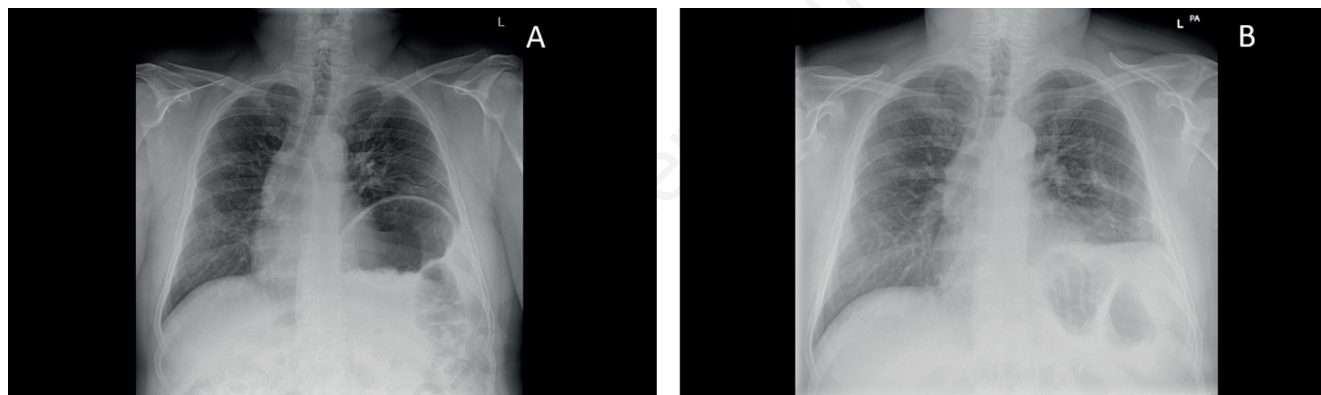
A) Chest radiograph of a 52-year-old man showing elevation of the left hemidiaphragm post COVID-19. B) Chest radiograph of the same patient following robotic-assisted surgical plication showing improved position of the left hemidiaphragm.
